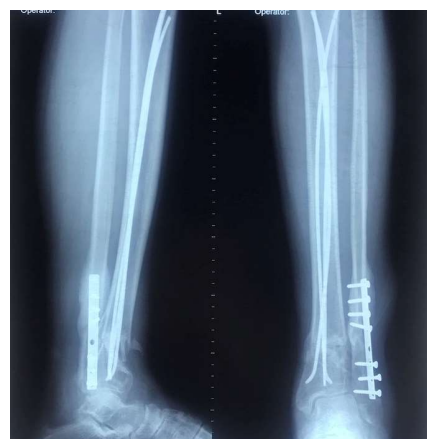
AP and lateral radiograph showing the union at 3rd month.
